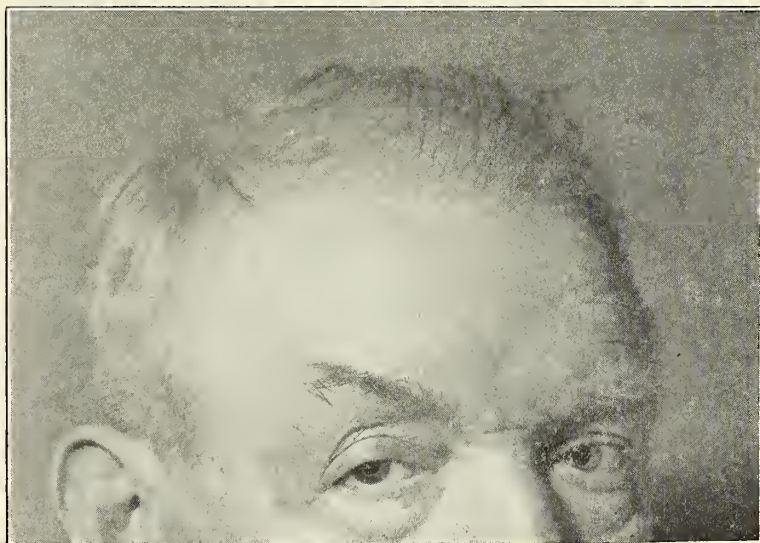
Same patient as Fig. 3. Basal cell epithelioma removed surgically, followed by treatment with Roentgen rays to the site of the tumor
